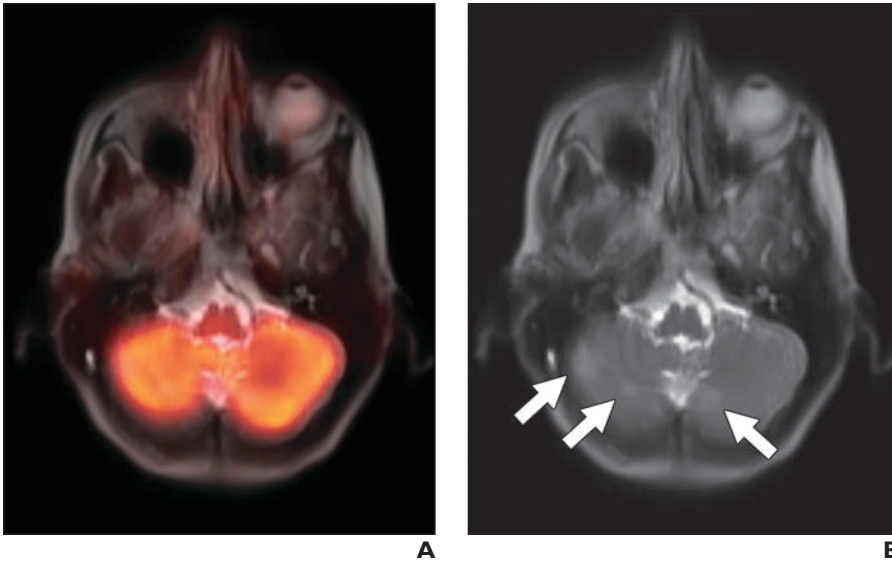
54-year-old woman with breast cancer and no neurologic symptoms. A, PET/MRI axial fusion image (A) shows no abnormal focal FDG uptake within cerebellum. B, Axial T2-weighted HASTE MR image shows three new foci of hyperintensity within cerebellar hemispheres that were suspicious for metastases (*arrows*). Other suspicious cerebral lesions were seen. Follow-up dedicated brain MRI confirmed multiple cerebral metastases.
